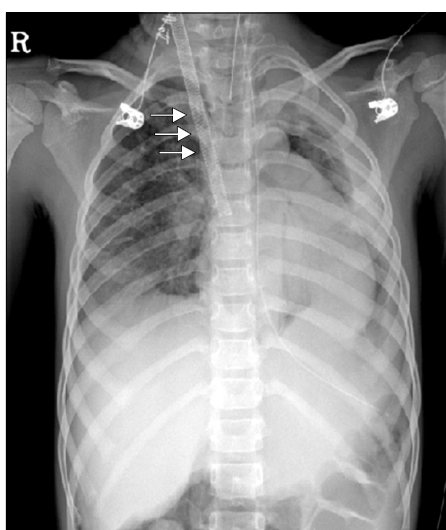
Chest X-ray immediately after application of extracorporeal membrane oxygenation. There was consolidation in the left upper lung zone, and an outflow catheter was inserted into the right internal jugular vein (arrows). R, right.
